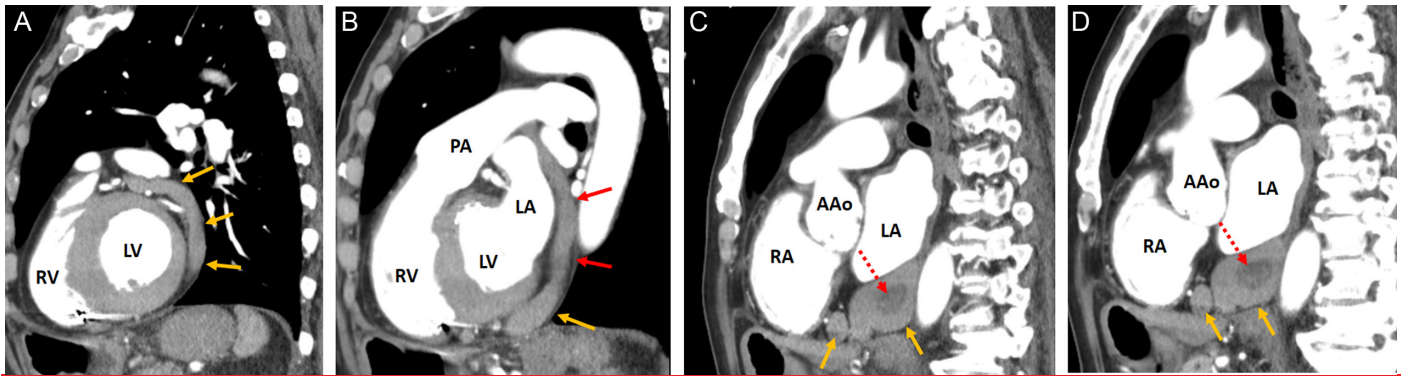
Consequence sagittal chest computed tomography angiography images (A-D) demonstrate the dilated coronary veins (yellow arrows), coronary sinus thrombosis (dashed red arrows), and persistent left superior vena cava (red arrows). RV, right ventricle; LV, left ventricle; RA, right atrium; LA, left atrium; AAo, ascending aorta; PA, pulmonary artery.
